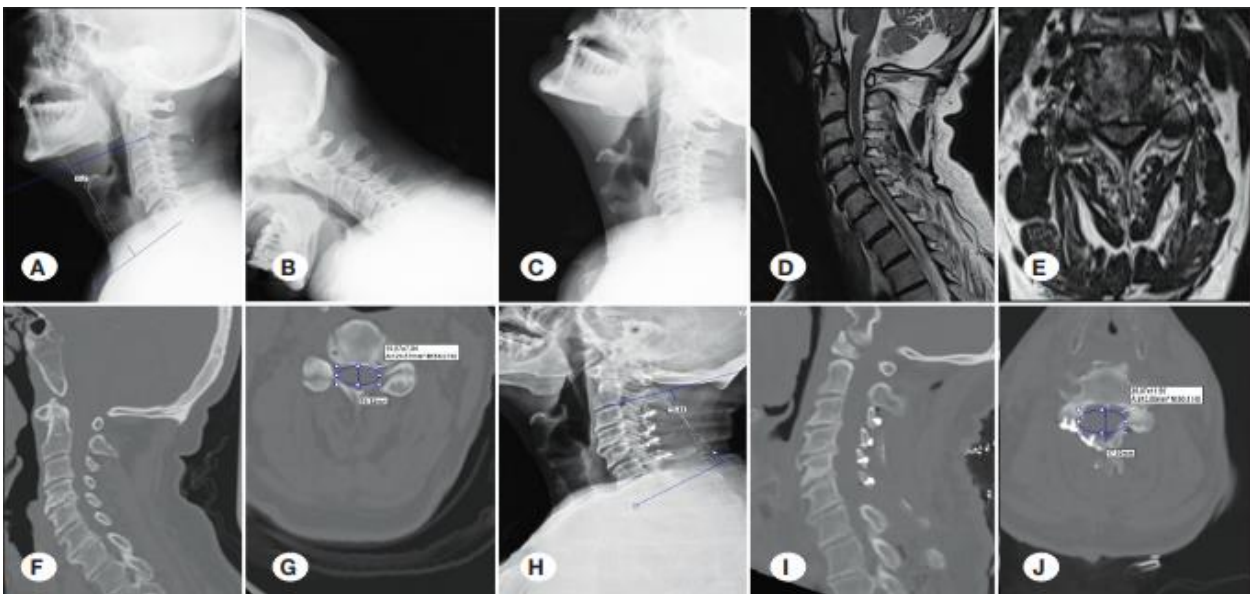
Preoperative radiographs (A) flexion; (B) extension; (C) preoperative sagittal; (D) axial; (E) CT and MRI sagittal; (F) axial; (G) CT scans postoperative; (H) lateral radiogram; (I) CT scan; sagittal and (J) CT scan; axial
